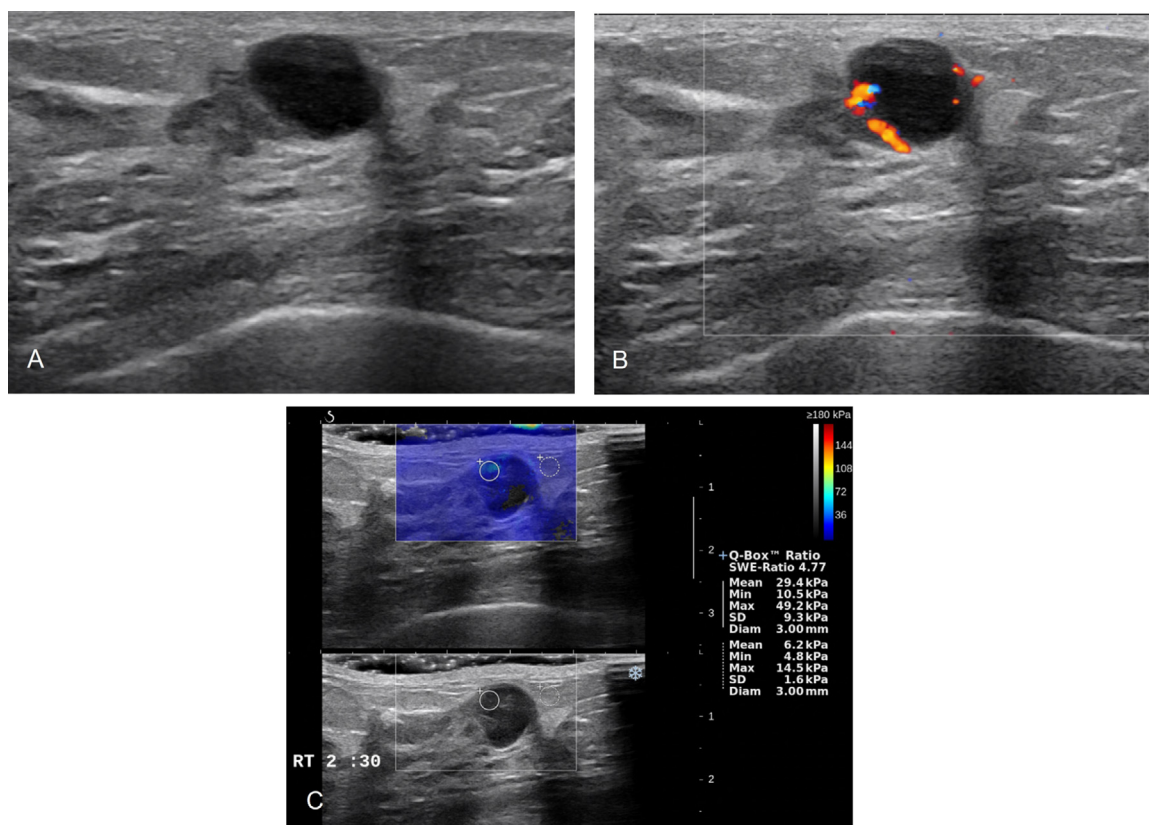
US of a 35-year-old woman with breast lymphoma (same patient as in Fig. 1). (A) Conventional US shows an oval markedly hypoechoic mass with circumscribed margins and posterior acoustic enhancement in upper inner area of right breast. (B) Color Doppler imaging shows vessels in the peripheral portion of mass. (C) SWE image shows E_{\max} of 49.2 kPa, E_{mean} of 29.4 kPa, and mean elasticity ratio of 4.77.
